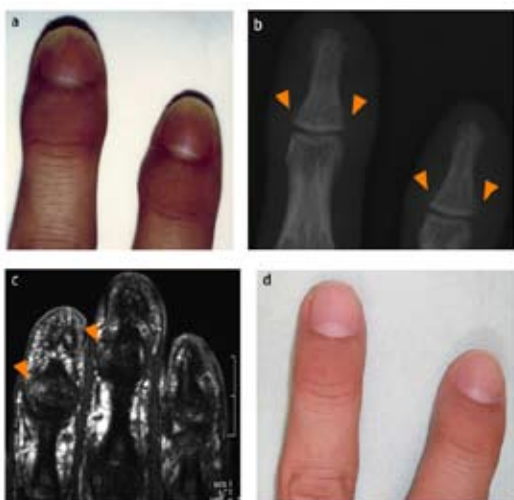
(a) Clinical features included edematous erythema on the acral parts of the fingers, pustules within the nail bed, and partial shedding of the nail plate; (b) bone x-ray image: arrows show bone erosion; (c) magnetic resonance imaging: arrows show the enhancement; (d) clinical feature: improvement of skin manifestation after the administration of infliximab and methotrexate.
